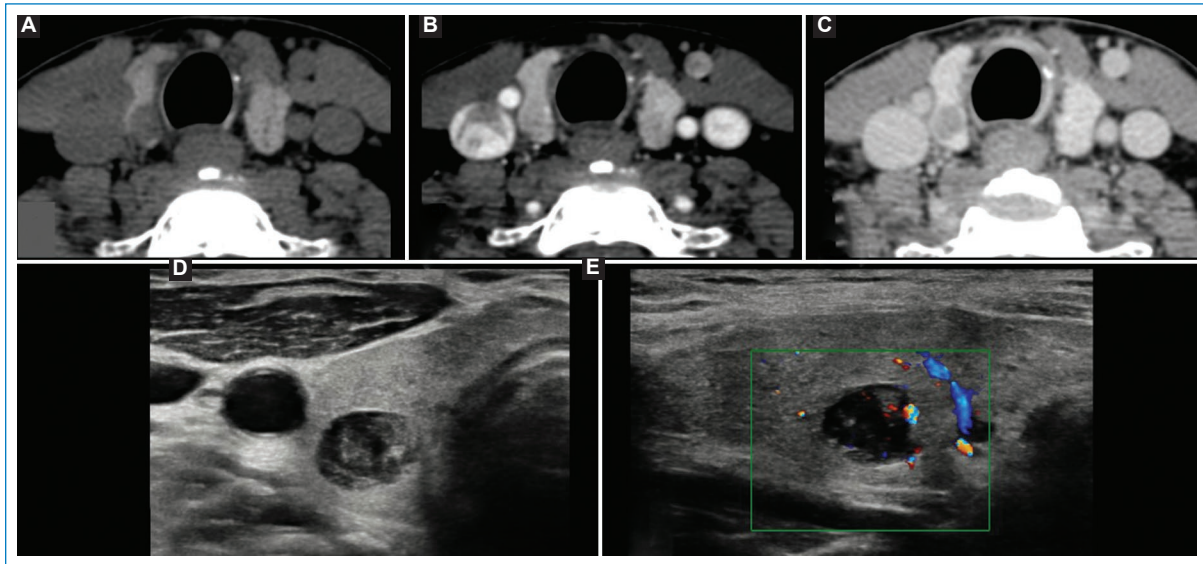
Ultrasound (US) as a guide for biopsy of lesions suspected of being adenomas. Computed tomography in non-contrast (A), arterial (B), and venous (C) phases showing a right intrathyroidal lesion with typical adenoma behavior in the dynamic study. Ultrasound correlation on the transverse (D) and longitudinal (E) planes allowed for a biopsy with a compatible result.
